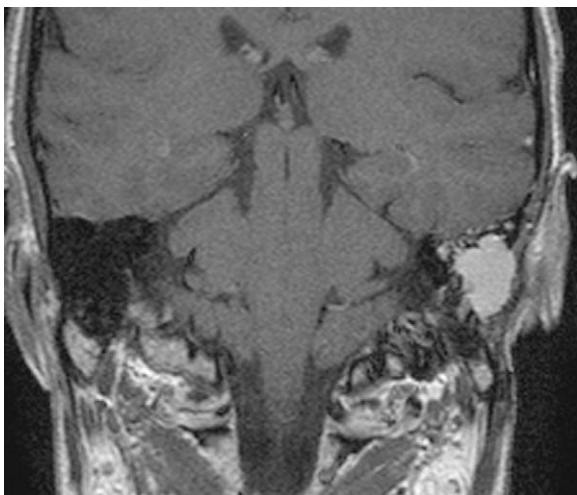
T1-weighted, coronal MR image demonstrates a hyperintense left mastoid cholesterol granuloma.
